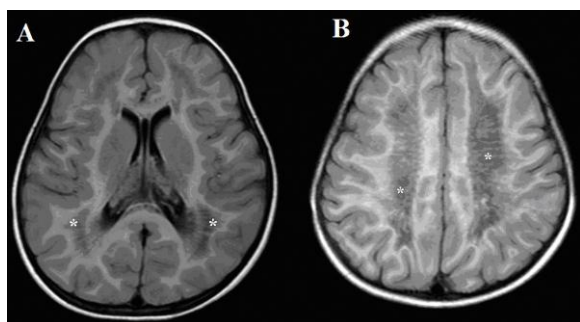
(A and B) are fluid attenuated inversion recovery magnetic resonance images with axial sections at basal ganglia and centrum semiovale respectively, shows diffuse white matter hyperintensity with areas of inversion (asterix, *) whose signal intensity is that of cerebrospinal fluid.
